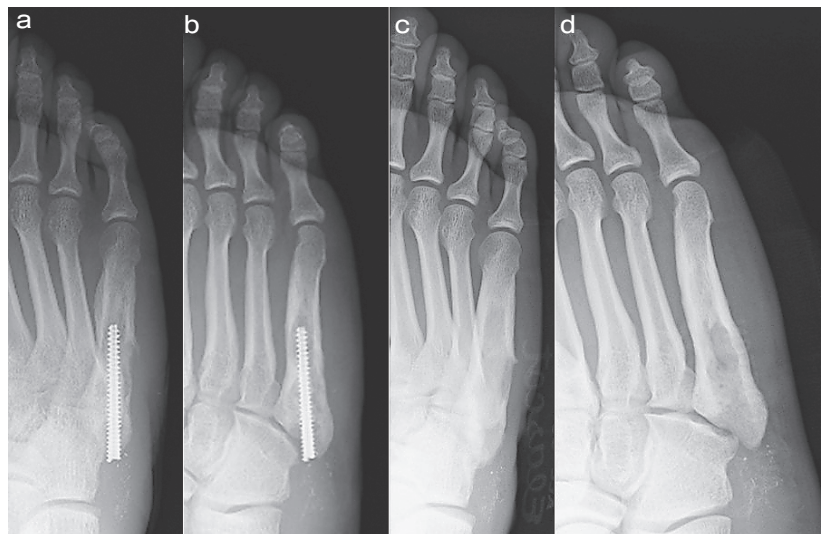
(Case 4) A-P (d) and oblique (e) foot X-ray images, Loosening around the screw was observed; A-P (c) and oblique (d) foot X-ray images, The screw was removed 1 year and 1 month postoperatively.
